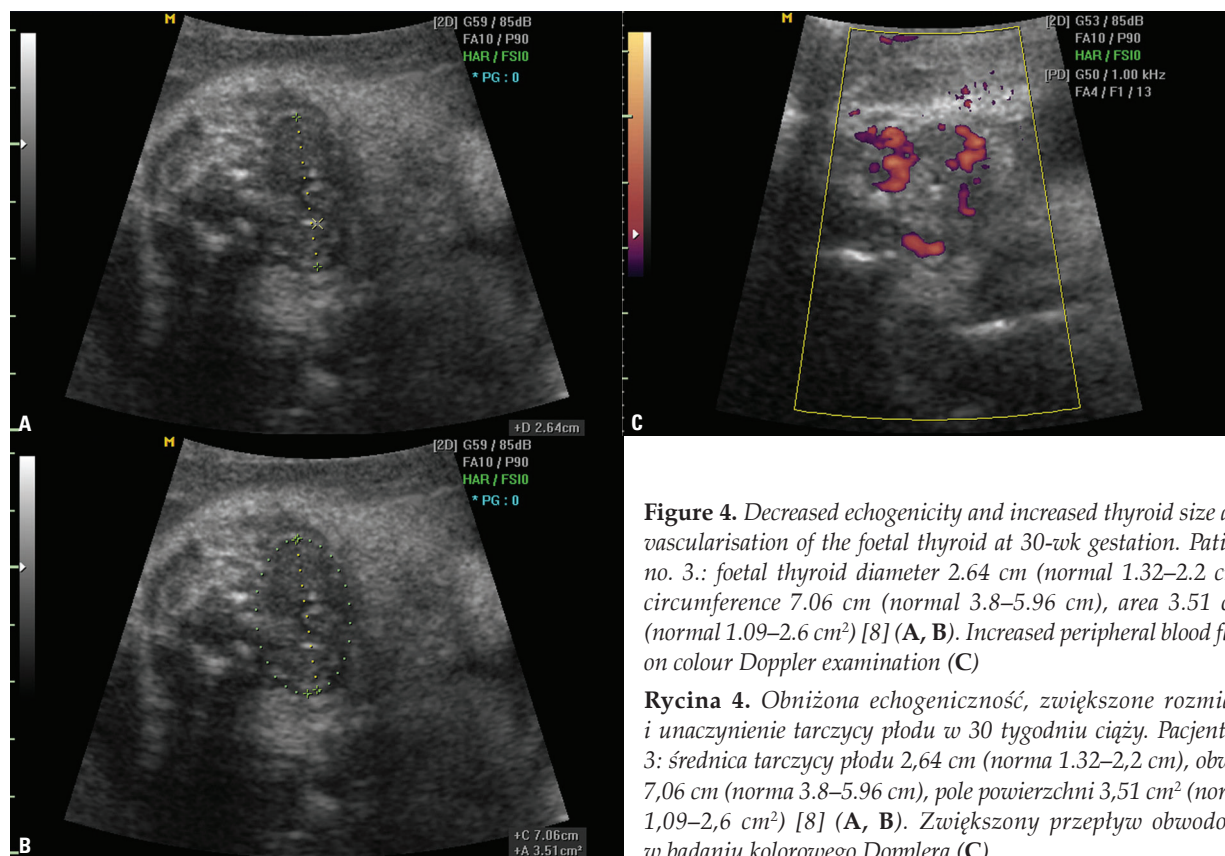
Decreased echogenicity and increased thyroid size and vascularisation of the foetal thyroid at 30-wk gestation. Patient no. 3.: foetal thyroid diameter 2.64 cm (normal 1.32–2.2 cm), circumference 7.06 cm (normal 3.8–5.96 cm), area 3.51 cm² (normal 1.09–2.6 cm²) [8] (A, B). Increased peripheral blood flow on colour Doppler examination (C)
